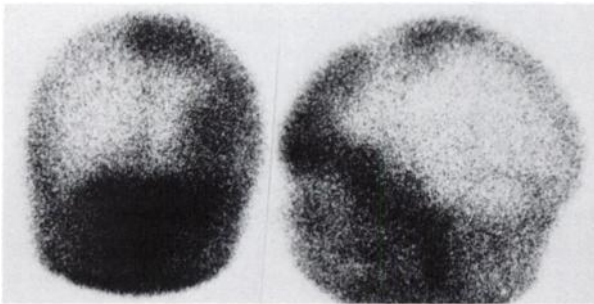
Pertechnetate static images: anterior and left lateral views at 30 min after injection show extensive uptake on left anteriorly in same area as radiographic abnormality.
